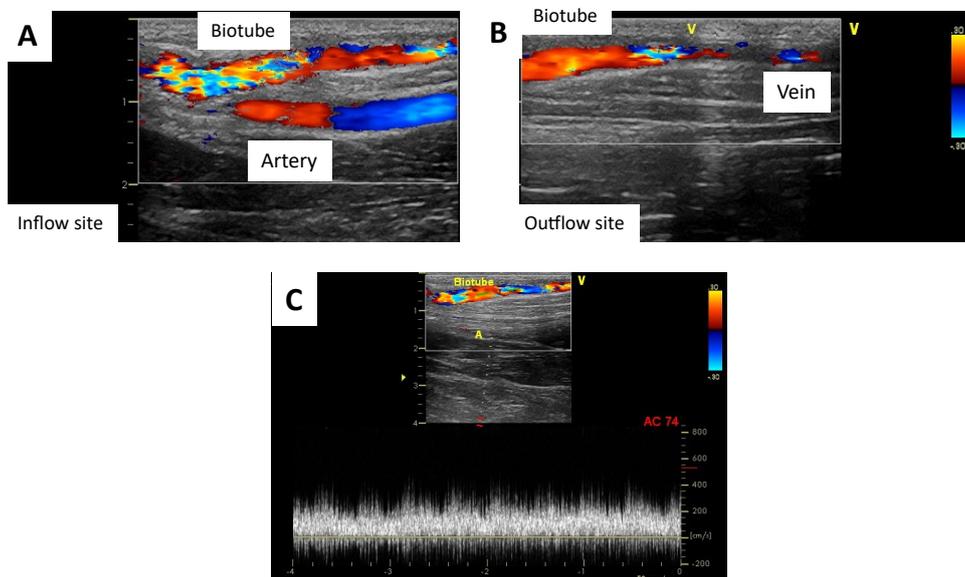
Ultrasound image of the Biotube implanted between the carotid artery and jugular vein (A, B). Turbulent blood flow and adequate blood volume through the Biotube were confirmed (C).
